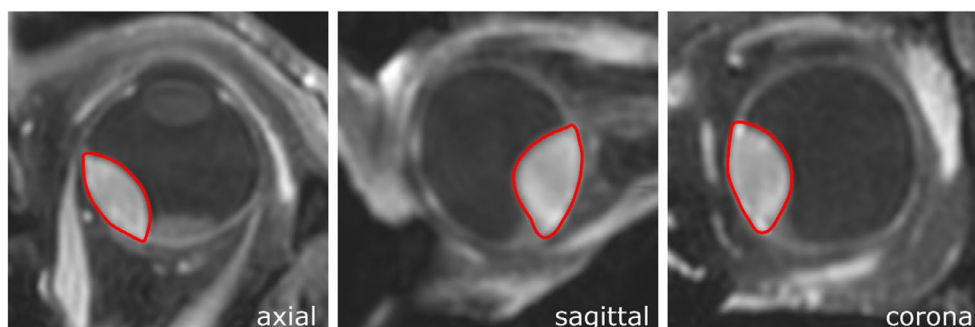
Tumour delineation (red contour) was performed on 3D contrast-enhanced T1-weighted MRI.
